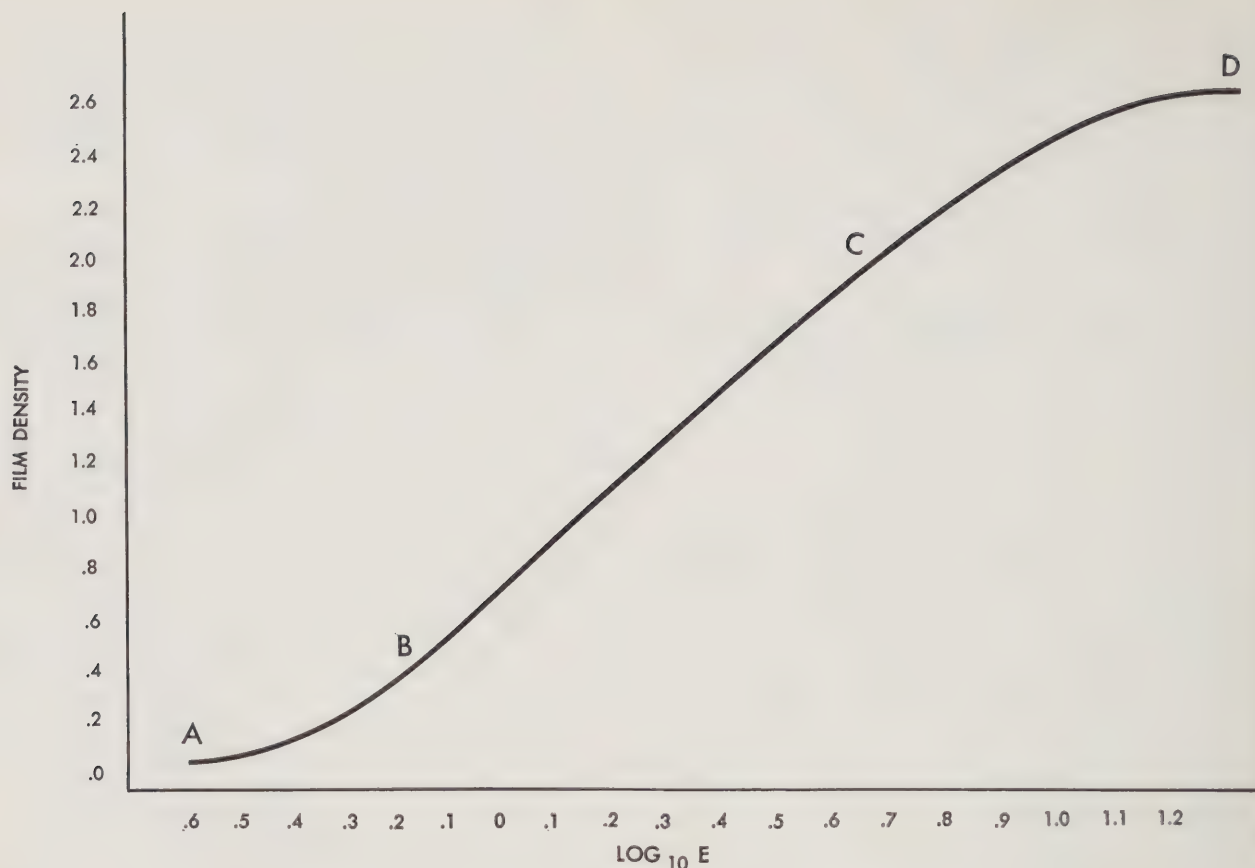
Photographic density curve of roentgen-ray films.
